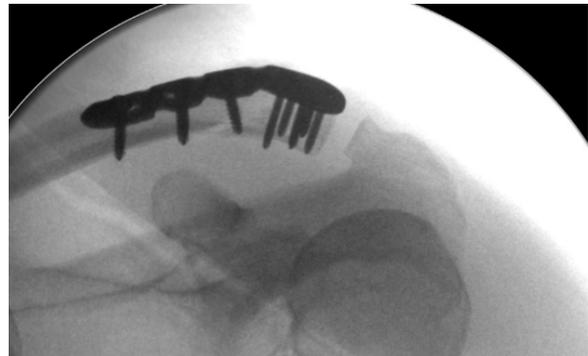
X-ray of a lateral clavicle locking plate.
